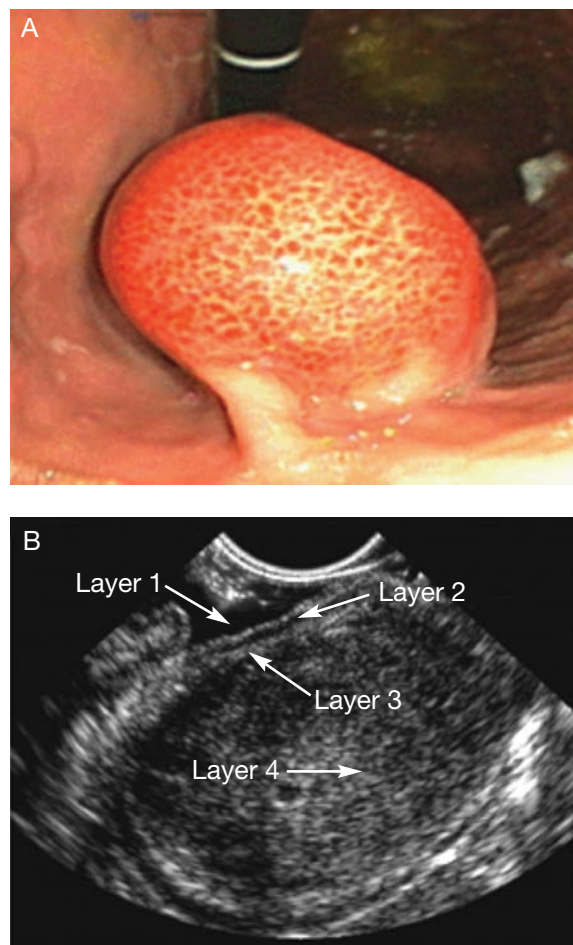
A, Endoscopic and, B, endoscopic ultrasonographic images of a pedunculated gastric gastrointestinal stromal tumor. Endoscopic ultrasonography can demonstrate five wall layers, but only four layers are seen in B. Layer 1 is hyperechoic (white) and is the superficial mucosa interface. Layer 2 is hypoechoic (black) and is deep mucosa. Layer 3 is hyperechoic and represents the submucosa. Layer 4 is the muscularis propria. It is hypoechoic (black) and is the layer of origin of most GISTs. (Courtesy of Dr. Michael J. Levy, Gastroenterology and Hepatology, Mayo Clinic.)
